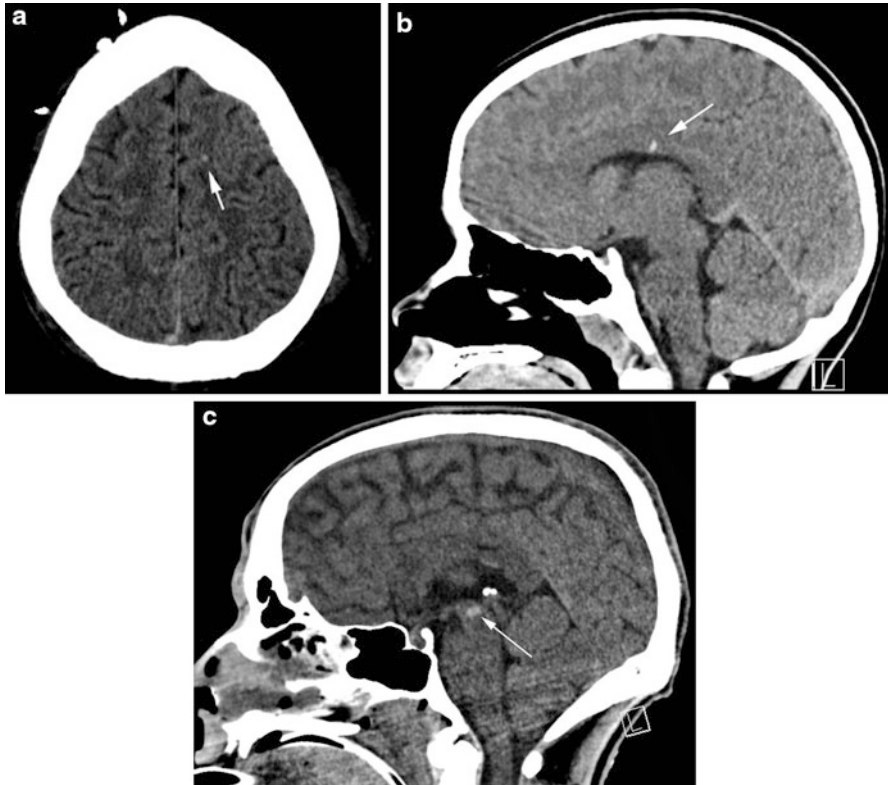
Diffuse axonal injury (DAI). Foci of hemorrhagic DAI in various patients imaged with CT. An axial noncontrast CT image (a) shows a focus of hyperdensity (*white arrow*) at the gray matter-white matter junction of the left frontal lobe. A sagittal noncontrast CT image (b) through the midline shows a focal hyperdensity (*white arrow*) within the body of the corpus callosum. A sagittal noncontrast CT image (c) shows a focal hyperdensity (*white arrow*) within the midbrain
